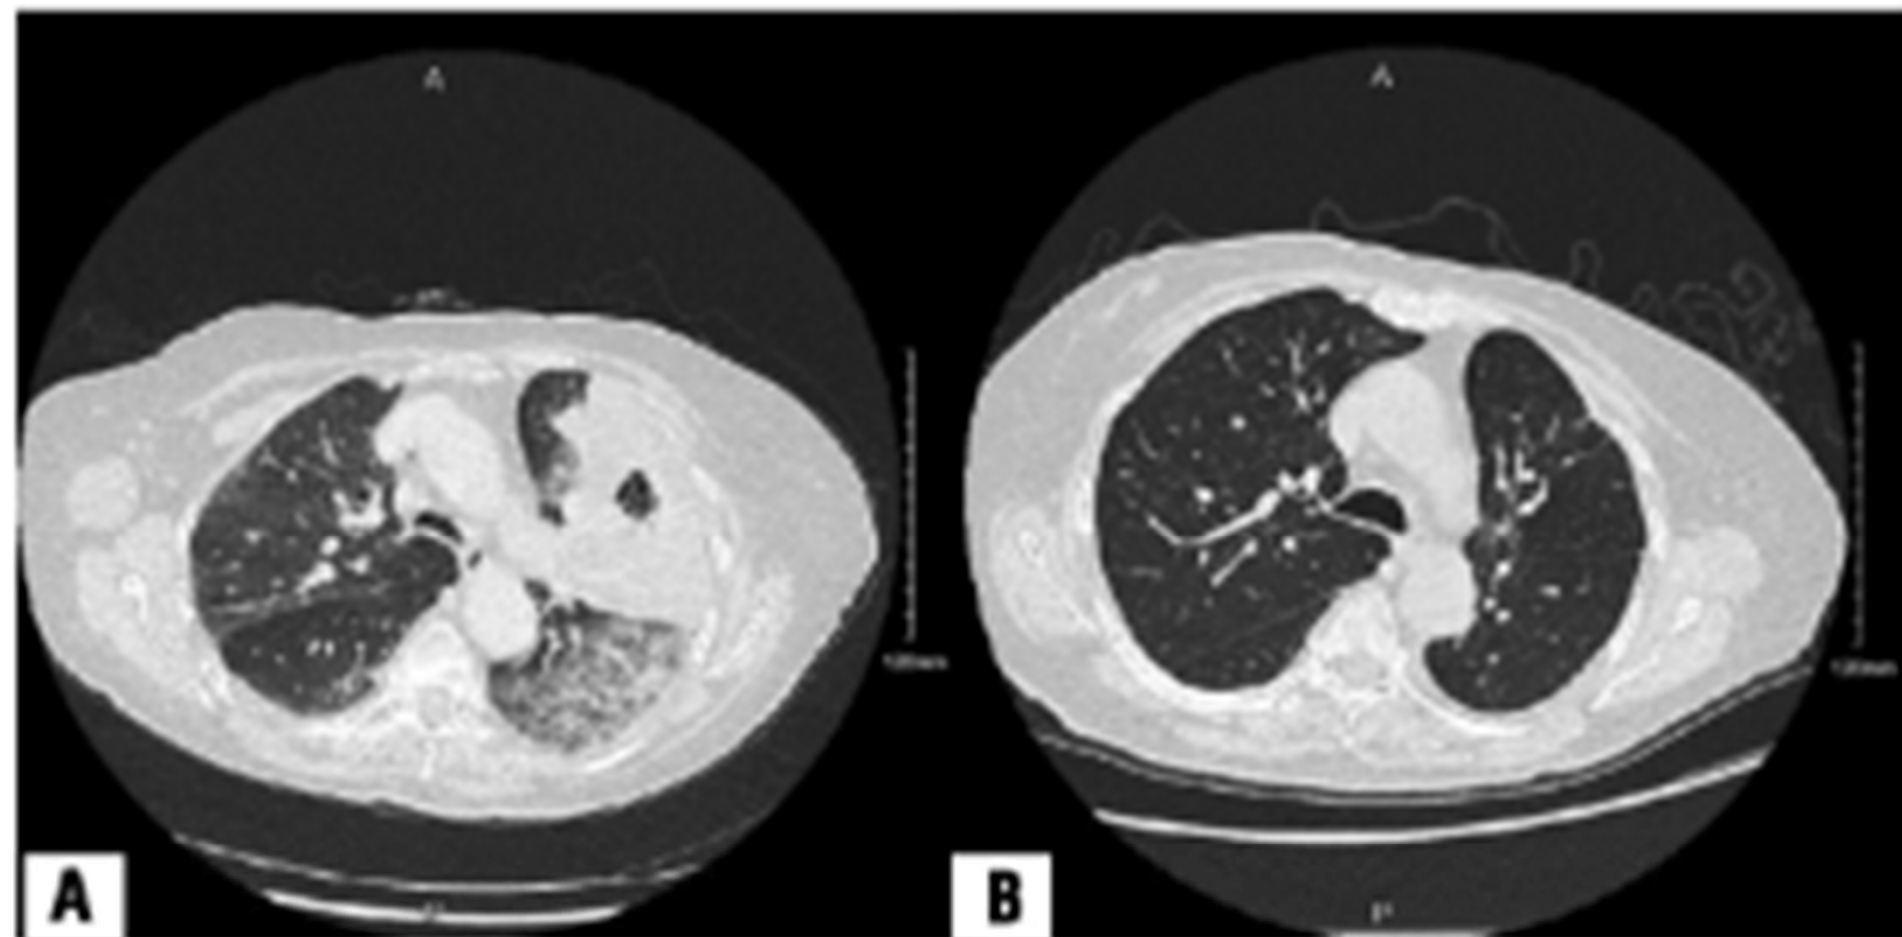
Axial computed tomography (CT) chest scans of a female patient in her late 80s, diagnosed with metastatic lung adenocarcinoma harbouring a *RET* rearrangement (*ERCL1* exon 17 to *RET* exon 12) treated with selpercatinib (A) at the time of diagnosis and (B) 9 months after starting therapy, showing radiographic response below the aortic arch.
